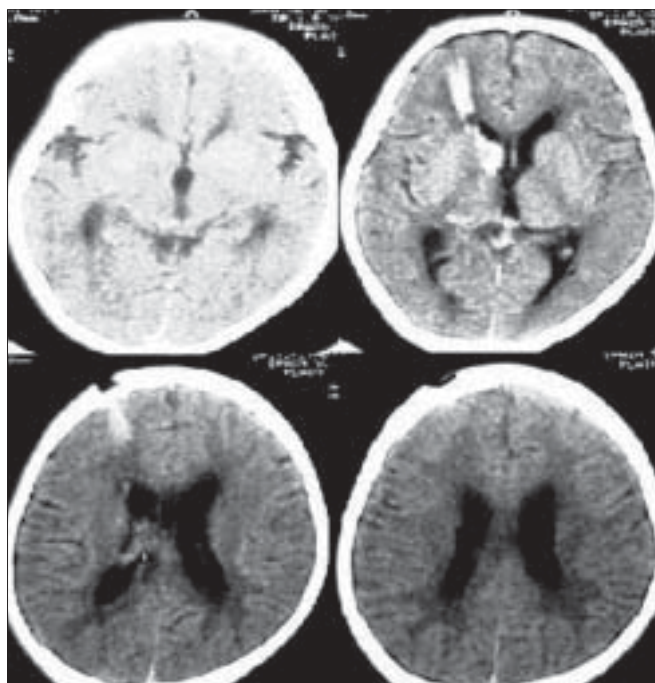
Post-operative CT scan showing complete aspiration of right thalamic abscess
